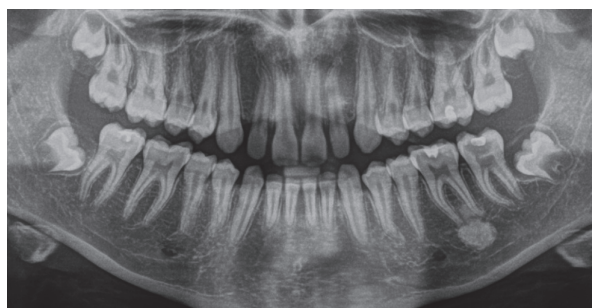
Orthopantomogram of a 16-year-old male patient (Patient K.); description provided in the text.
